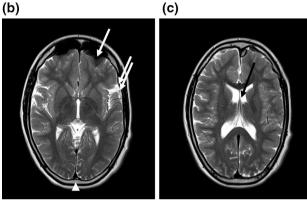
MRI brain scans of patient. (a) Mid sagittal T1-weighted image shows measures of the brain stem larger than normal. (b) Axial T2-weighted image at the level of opercula showed big pneumatized frontal sinus (white arrow), width diploe (arrowhead), and opercular dysplasia (double white arrow). (c) Axial T2-weighted image at the level of lateral ventricles showed large ventricles (black arrow).
